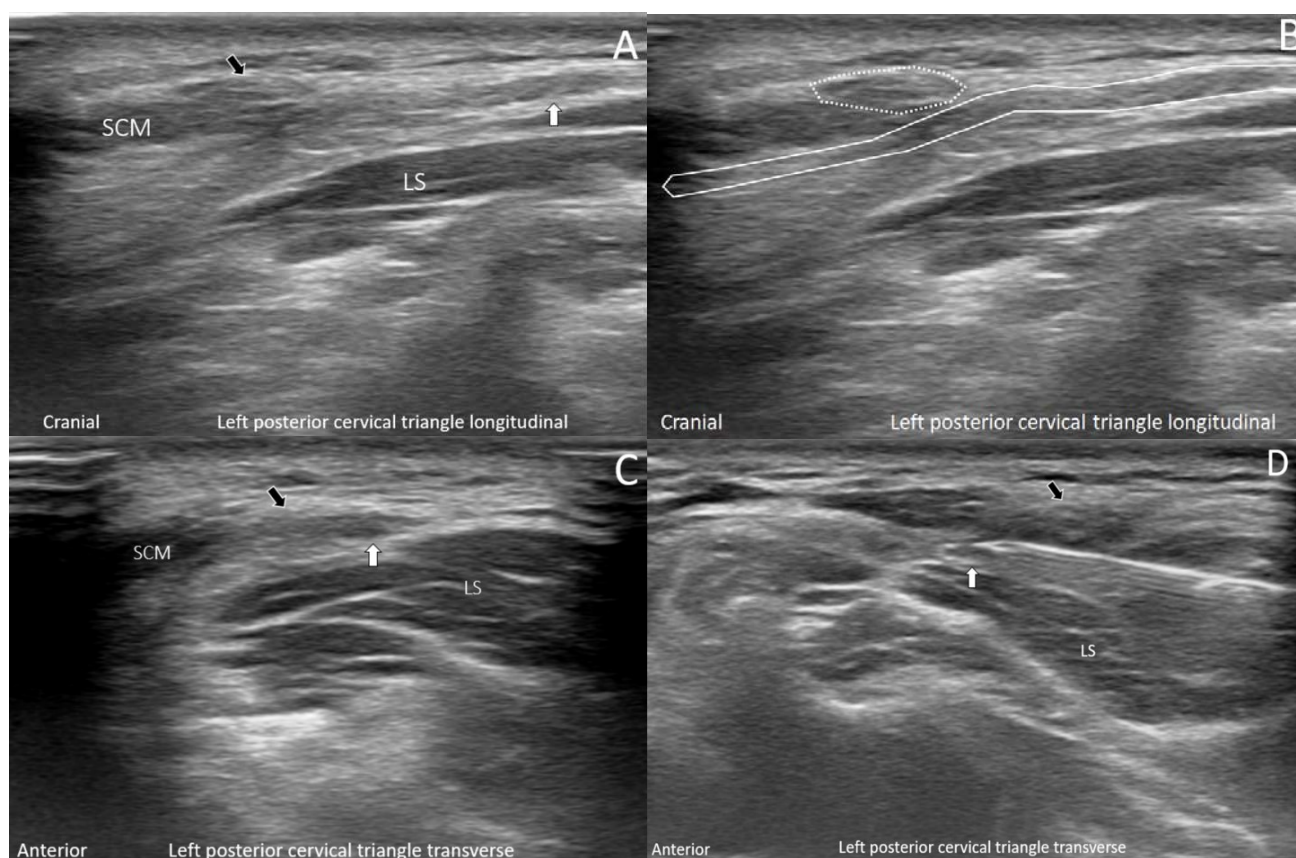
(A)(B) Longitudinal scan of the left spinal accessory nerve (SAN) (white arrow and solid white line). The swelling of the SAN is 3 to 5 mm away from the scar tissue (black arrow and dashed white line), suggesting compression-induced retrograde swelling of the SAN. Unlike direct injury, where the swelling or neuroma is formed right beneath the scar, the left SAN is partially damaged because of scar adhesion after surgery. (C) Transverse scan along the left SAN revealed adhesion between the left SAN and the surrounding tissue of the surgical scar. The swollen SAN is in the posterior cervical triangle, which is located posterior to the SCM and anterior to the trapezius muscle. (D) Hydrodissection of the SAN was performed under ultrasound guidance (transverse scan, in-plane approach, posterior to anterior). SCM, sternocleidomastoid muscle; LS, levator scapula muscle.
